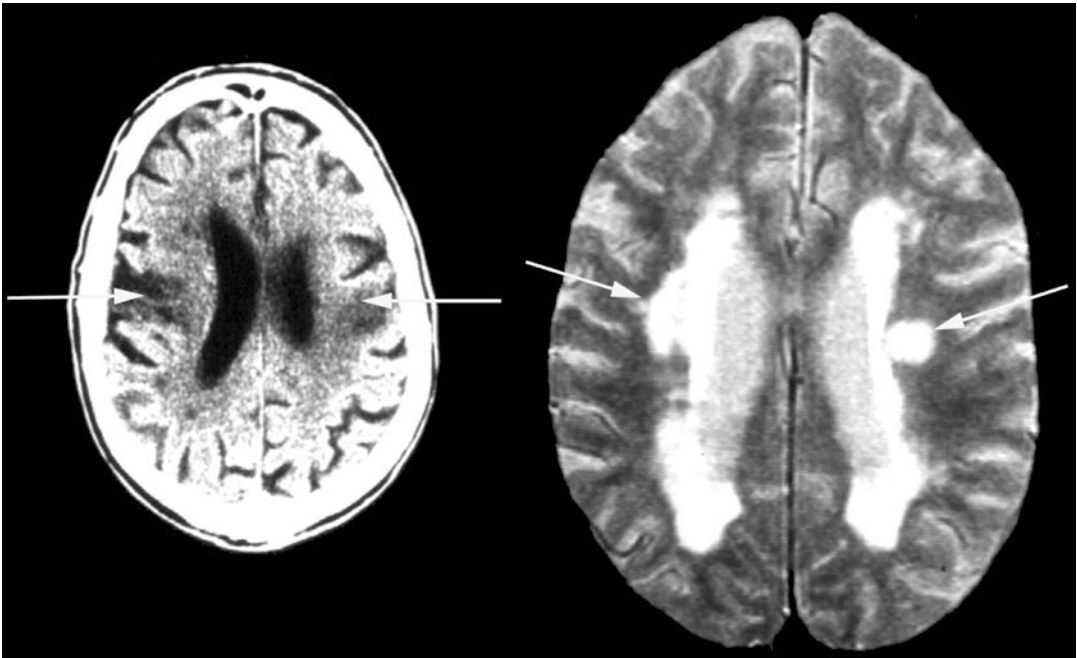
Left:* Cranial computed tomography showing bilateral infarctions (*arrows*) in the supply area of the middle cerebral artery affecting the frontoparietal operculum bilaterally causing the so-called bilateral anterior frontoparietal opercular syndrome (Foix-Chavany-Marie
